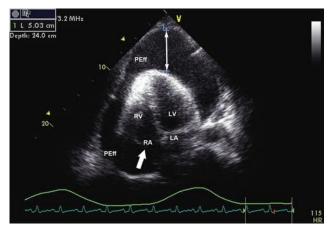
Cardiac tamponade: 2D apical four-chamber view of a patient with a large PEff and cardiac tamponade as evidenced by RA systolic collapse (Video A3). Of note, RA collapse (one-headed arrow) may occur in diastole or systole, and the longer the proportion of the cardiac cycle during which collapse is present, the greater the specificity that cardiac tamponade is present. In this example, the largest collection (~5 cm) of fluid is at the apex (two-headed arrow), and pericardiocentesis can be performed from this approach.
